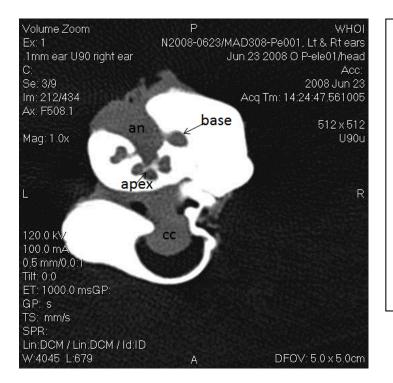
2D CT scan of right melon head ear at the level of the cochlea. In cross-section the cochlear spiral appears like a broad clover shape with central branch, the auditory nerve bundle (an) with oval leaves (the cochlear canal). The cochlear canal diameter at the base averages 1.7 mm in this species. The smaller vestibular system is not shown because it resides in the periotic posterior and at right angles to the cochlear (see fig. 5).
